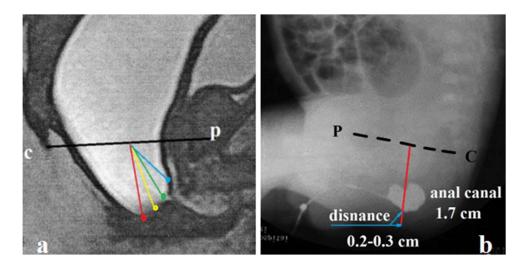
Low ARM (a). MRI with augmented-pressure distal colostogram in male with anourethral ectopy. The normal position of the anus is red, perineal ectopy is yellow, bulbar ectopy is green, and prostatic ectopy is blue. (b). Fistulography in newborn male through the fistulous opening on the sagittal raphe under the scrotum. The contrast agent depot is determined in the opened anal canal 2-3 mm from the anal dimple.
